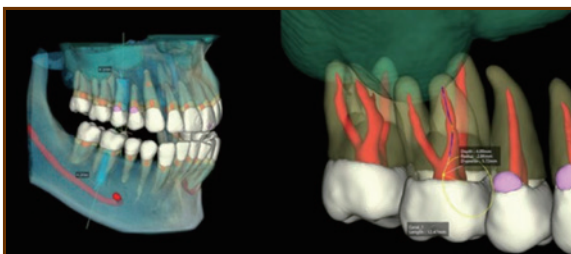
CBCT Segmentation (Courtesy of Vatech)
